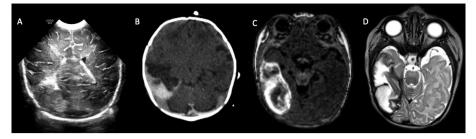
Subpial hemorrhage. A 17-day-old female with hypoplastic left heart syndrome status post Stage I Norwood with BT shunt. Coronal sonographic images (A) shows a heterogeneous lesion in the right temporal lobe. Axial non-contrast CT (B) shows the lesion to be a mixed intensity peripheral lesion in the right temporal lobe. T1- (C) and T2-weighted (D) images demonstrate a subpial hematoma in the right temporal lobe.
